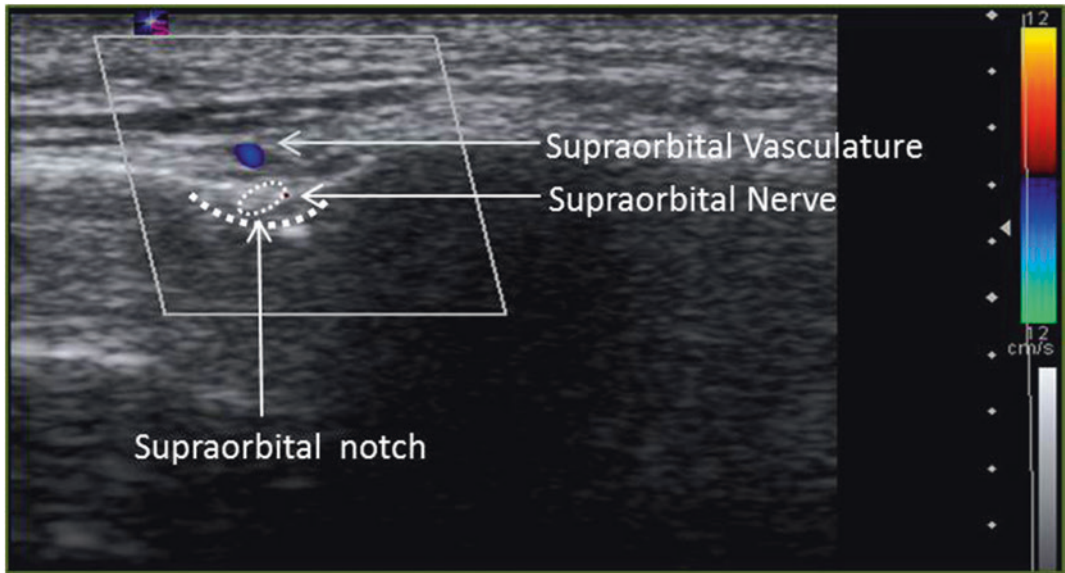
Ultrasound image for supraorbital nerve block
